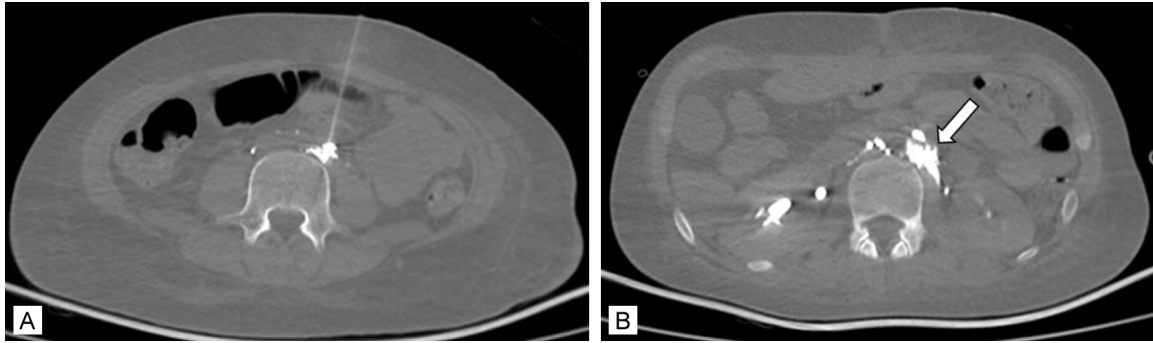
Under CT guidance, the left lumbar lymphatic duct inferior to the aberrant collateral lymphatics was accessed percutaneously with a 22-gauge Chiba needle. A. A mixture of NBCA and lipiodol (NBCA:lipiodol = 1:3) was injected into the left lumbar lymphatics below aberrant collateral lymphatics. B. Lipiodol-NBCA accumulation in and around collateral lymphatics after injection (arrow).
